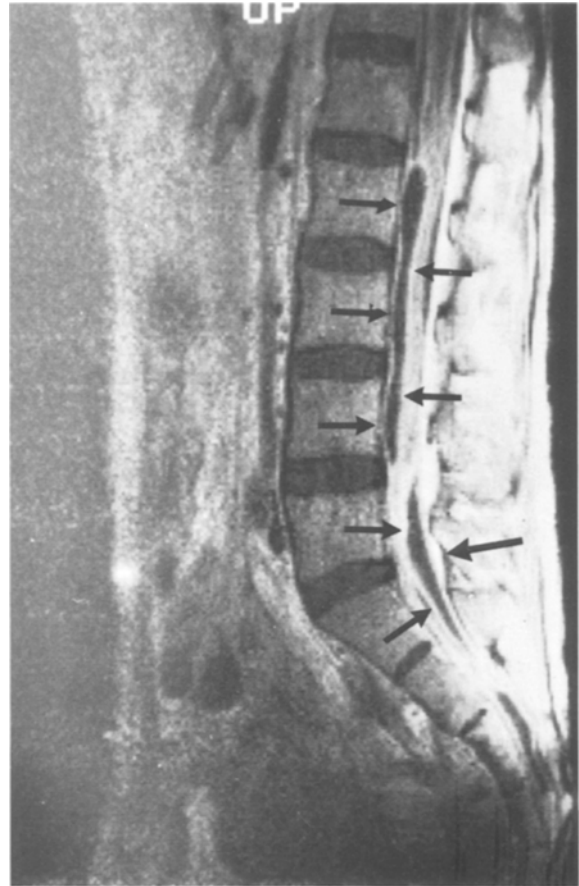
Sagittal, T1-weighted contrast-enhanced MR-image of a 30 years old woman suffering from Crohn's disease with fistula findings, showing multiple subdural abscesses (arrows). The membrane demonstrates characteristically high signal intensity because of contrast enhancement, the intramembraneous pus remains of low signal intensity. The longitudinal extension of the lesion can be visualized
